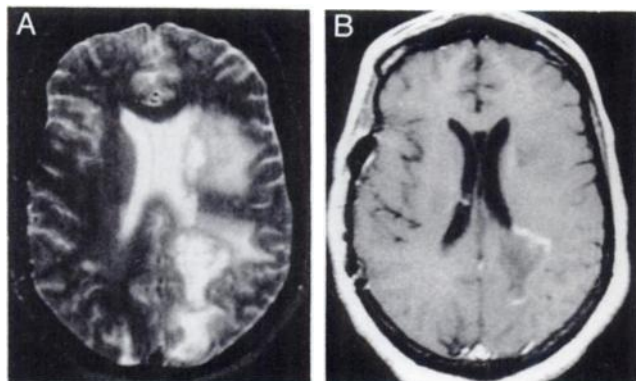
Second MR (1.5T) 4 wk later: (A) T2-weighted MR (TR 3000/TE 90) reveals large mass lesions within the left hemisphere. (B) In contrast to the first scan Gd-DTPA enhancement in the T1-weighted image (TR 600/TE 20) is decreased.
